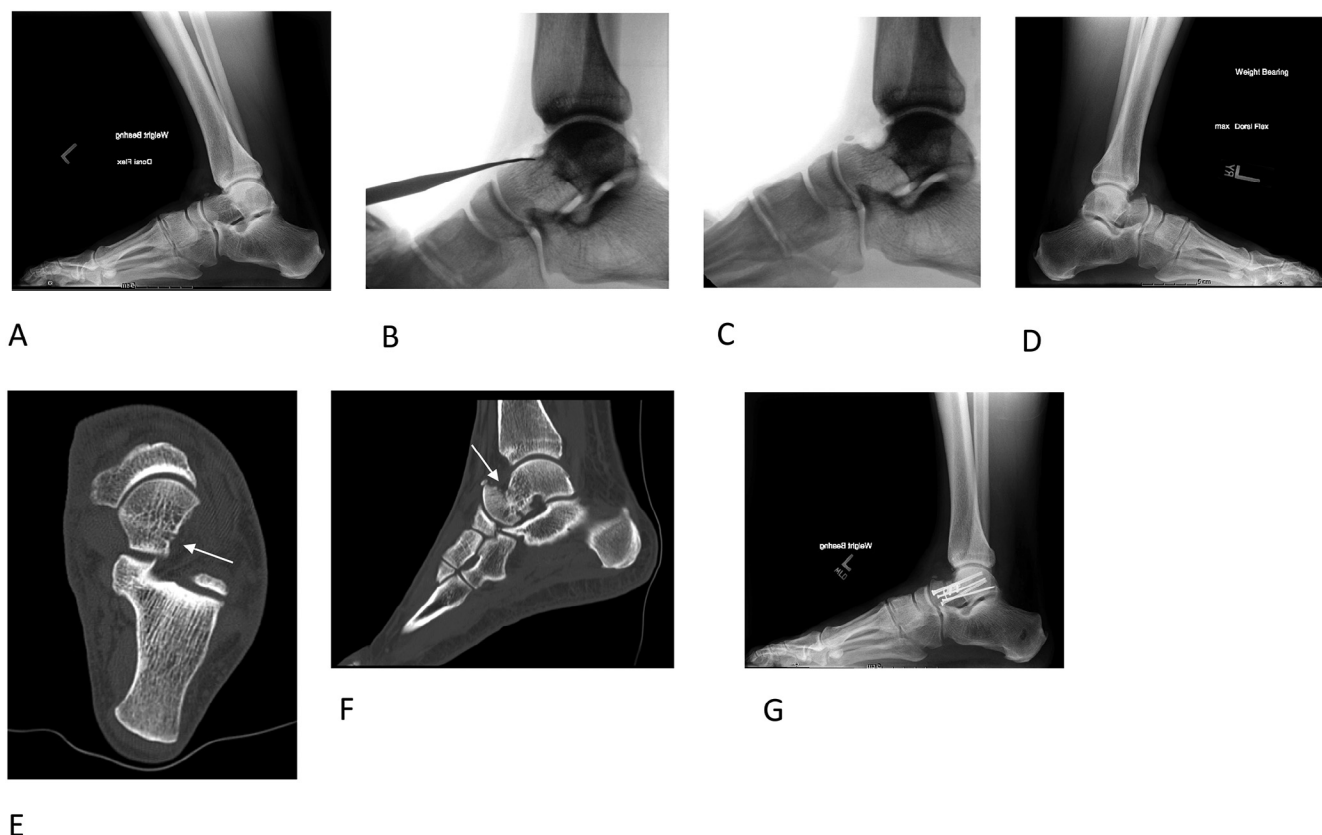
A 45-year-old man with cheilectomy complicated by a talar neck insufficiency fracture. (A) The lateral radiograph of the ankle in dorsiflexion demonstrates tibiotalar osteoarthritis with osteophytosis at the talar neck. There is no significant motion restriction with dorsiflexion. The patient subsequently underwent ankle cheilectomy with a removal of the osteophyte at the talar neck, demonstrated by the 2 intraoperative fluoroscopic images (B and C). Four weeks after the ankle cheilectomy, a lateral radiograph of the ankle in dorsiflexion (D) demonstrates a fracture through the neck of the talus. This was confirmed by computed tomography with axial (E) and sagittal (F) images demonstrating a fracture through the talar neck extending from the cheilectomy site to the middle facet of the subtalar joint (arrows). The patient subsequently underwent open reduction and internal fixation of the talar neck (G).
